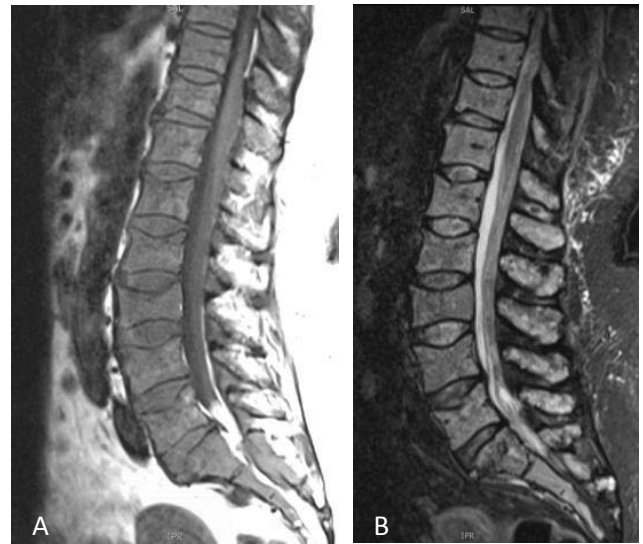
Sagittal T1 (A) and T2 (B) MR images demonstrate heterogeneous bone marrow signal with subtle endplate deformities. Coronal T1 pre (C) and post (D) contrast images of the sacrum reveal an enhancing left sacral mass. Frontal skull radiograph (E) demonstrates numerous lytic calvarial lesions. Coronal FLAIR image of the brain (F) shows increased signal intensity associated with the calvarial lesions.
